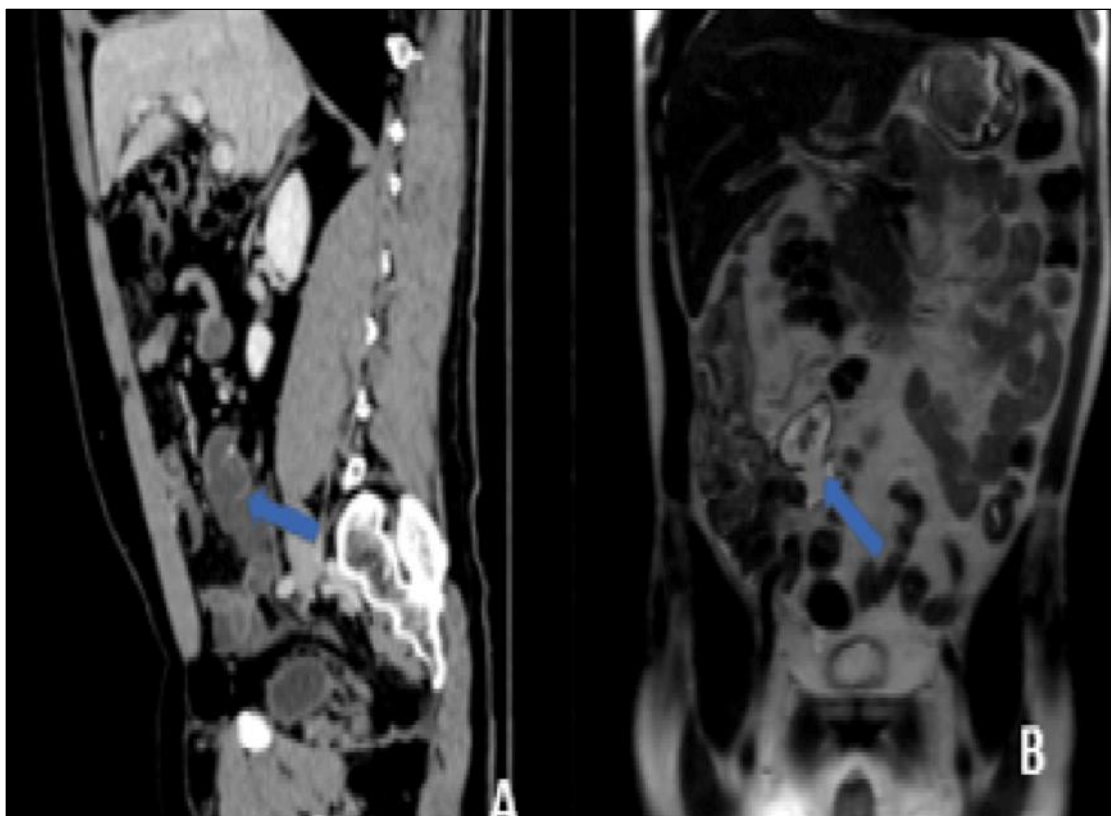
Contrast-enhanced sagittal CT (A) and coronal T2-weighted MRI showing focal discontinuity of the wall of the appendiceal lesion at its inferior pole(arrow), with prolapse of its mucinous content into the adjacent peritoneal space.
